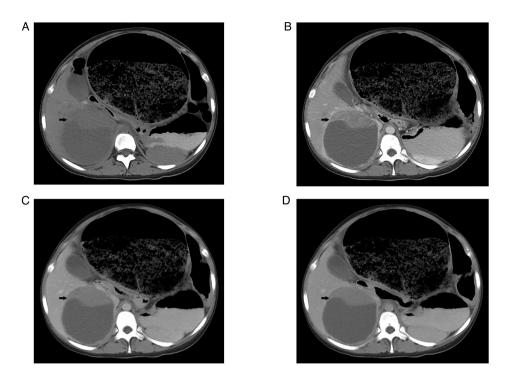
Preoperative abdominal and contrast-enhanced CT images. (A) Abdominal CT scan revealed a large, round and hypodense mass with a solid and well marginated periphery (arrow). (B) Abdominal contrast-enhanced CT images revealed that the solid portion displayed intense enhancement in the arterial phase (arrow). Enhancement was also observed (arrow) at the (C) portal and (D) delayed phases. The sigmoid colon and rectum were well distended and expanded and filled with gas and intestinal contents.
